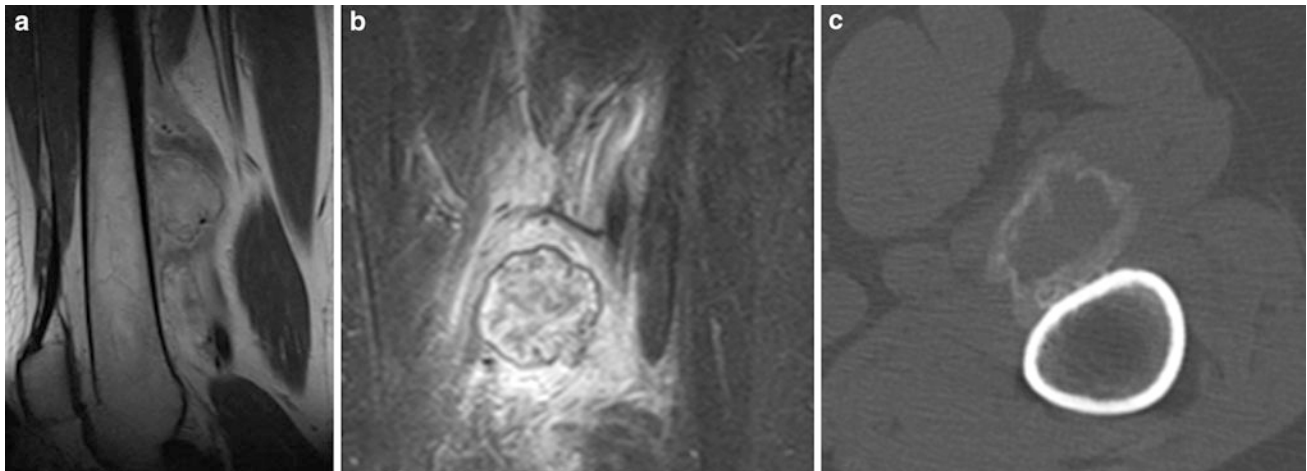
Sagittal T2-weighted MR image (a), coronal STIR MR image (b) and axial CT image (c) show myositis ossificans immediately adjacent to the posterior aspect of the mid to distal shaft of the femur in a 32-year-old female patient who developed local pain and a
